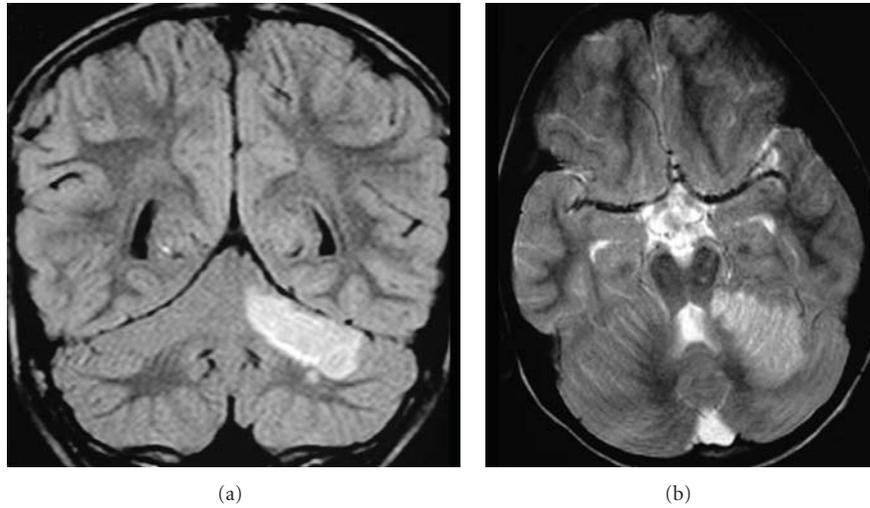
MRI coronal FLAIR (a) and axial T2-weighted (b) images show an infarction in the left superior cerebellar hemisphere, in the territory of one hemispheric branch of the left SCA.
